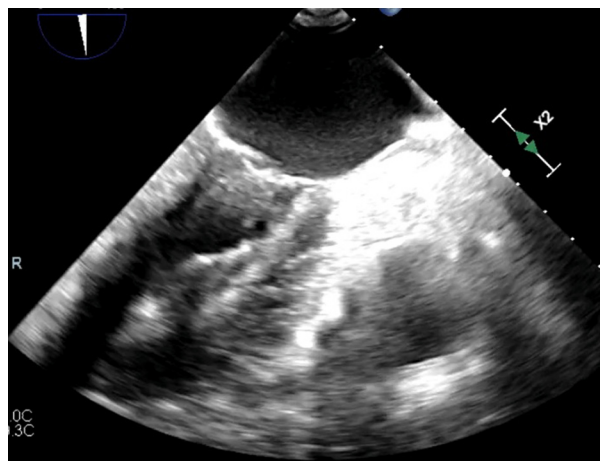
Transesophageal echocardiography showing successful left atrial appendage closure after clip.
